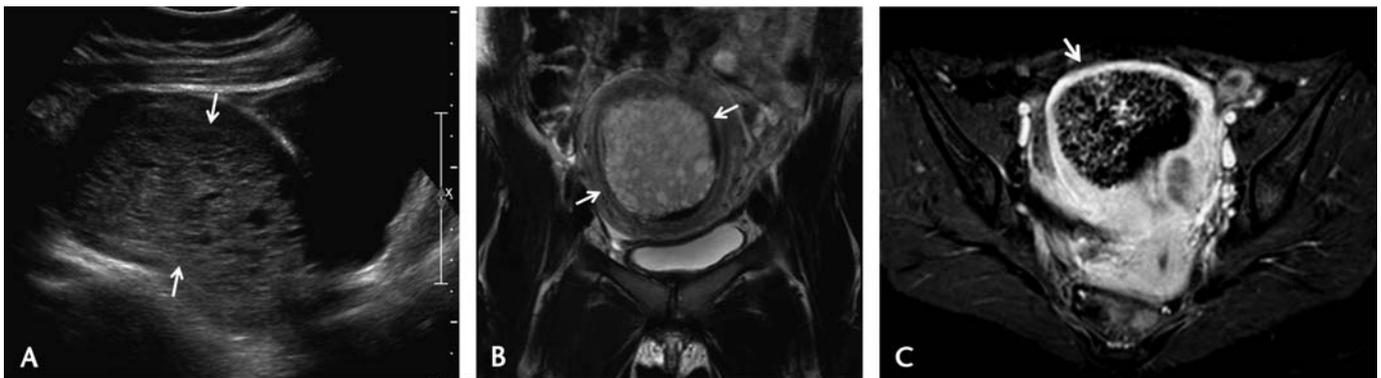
Complete hydatidiform mole. A, Sagittal gray scale ultrasound image at 10-week gestation in a patient with a markedly elevated human chorionic gonadotropin (HCG) level shows a cystic mass filling the entire endometrial cavity (arrows). During the ultrasound examination, there was suspicion for myometrial invasion (not shown), and an MRI was requested for clarification. B, Coronal T2-weighted magnetic resonance image shows the heterogeneous cystic mass filling the endometrial cavity (arrows). C, T1-weighted axial postcontrast administration magnetic resonance image in the same patient shows enhancement of the mass with apparent cystic spaces. There was no evidence of myometrial invasion on MRI. The diagnosis of a complete molar pregnancy was confirmed on pathological evaluation (not shown).
